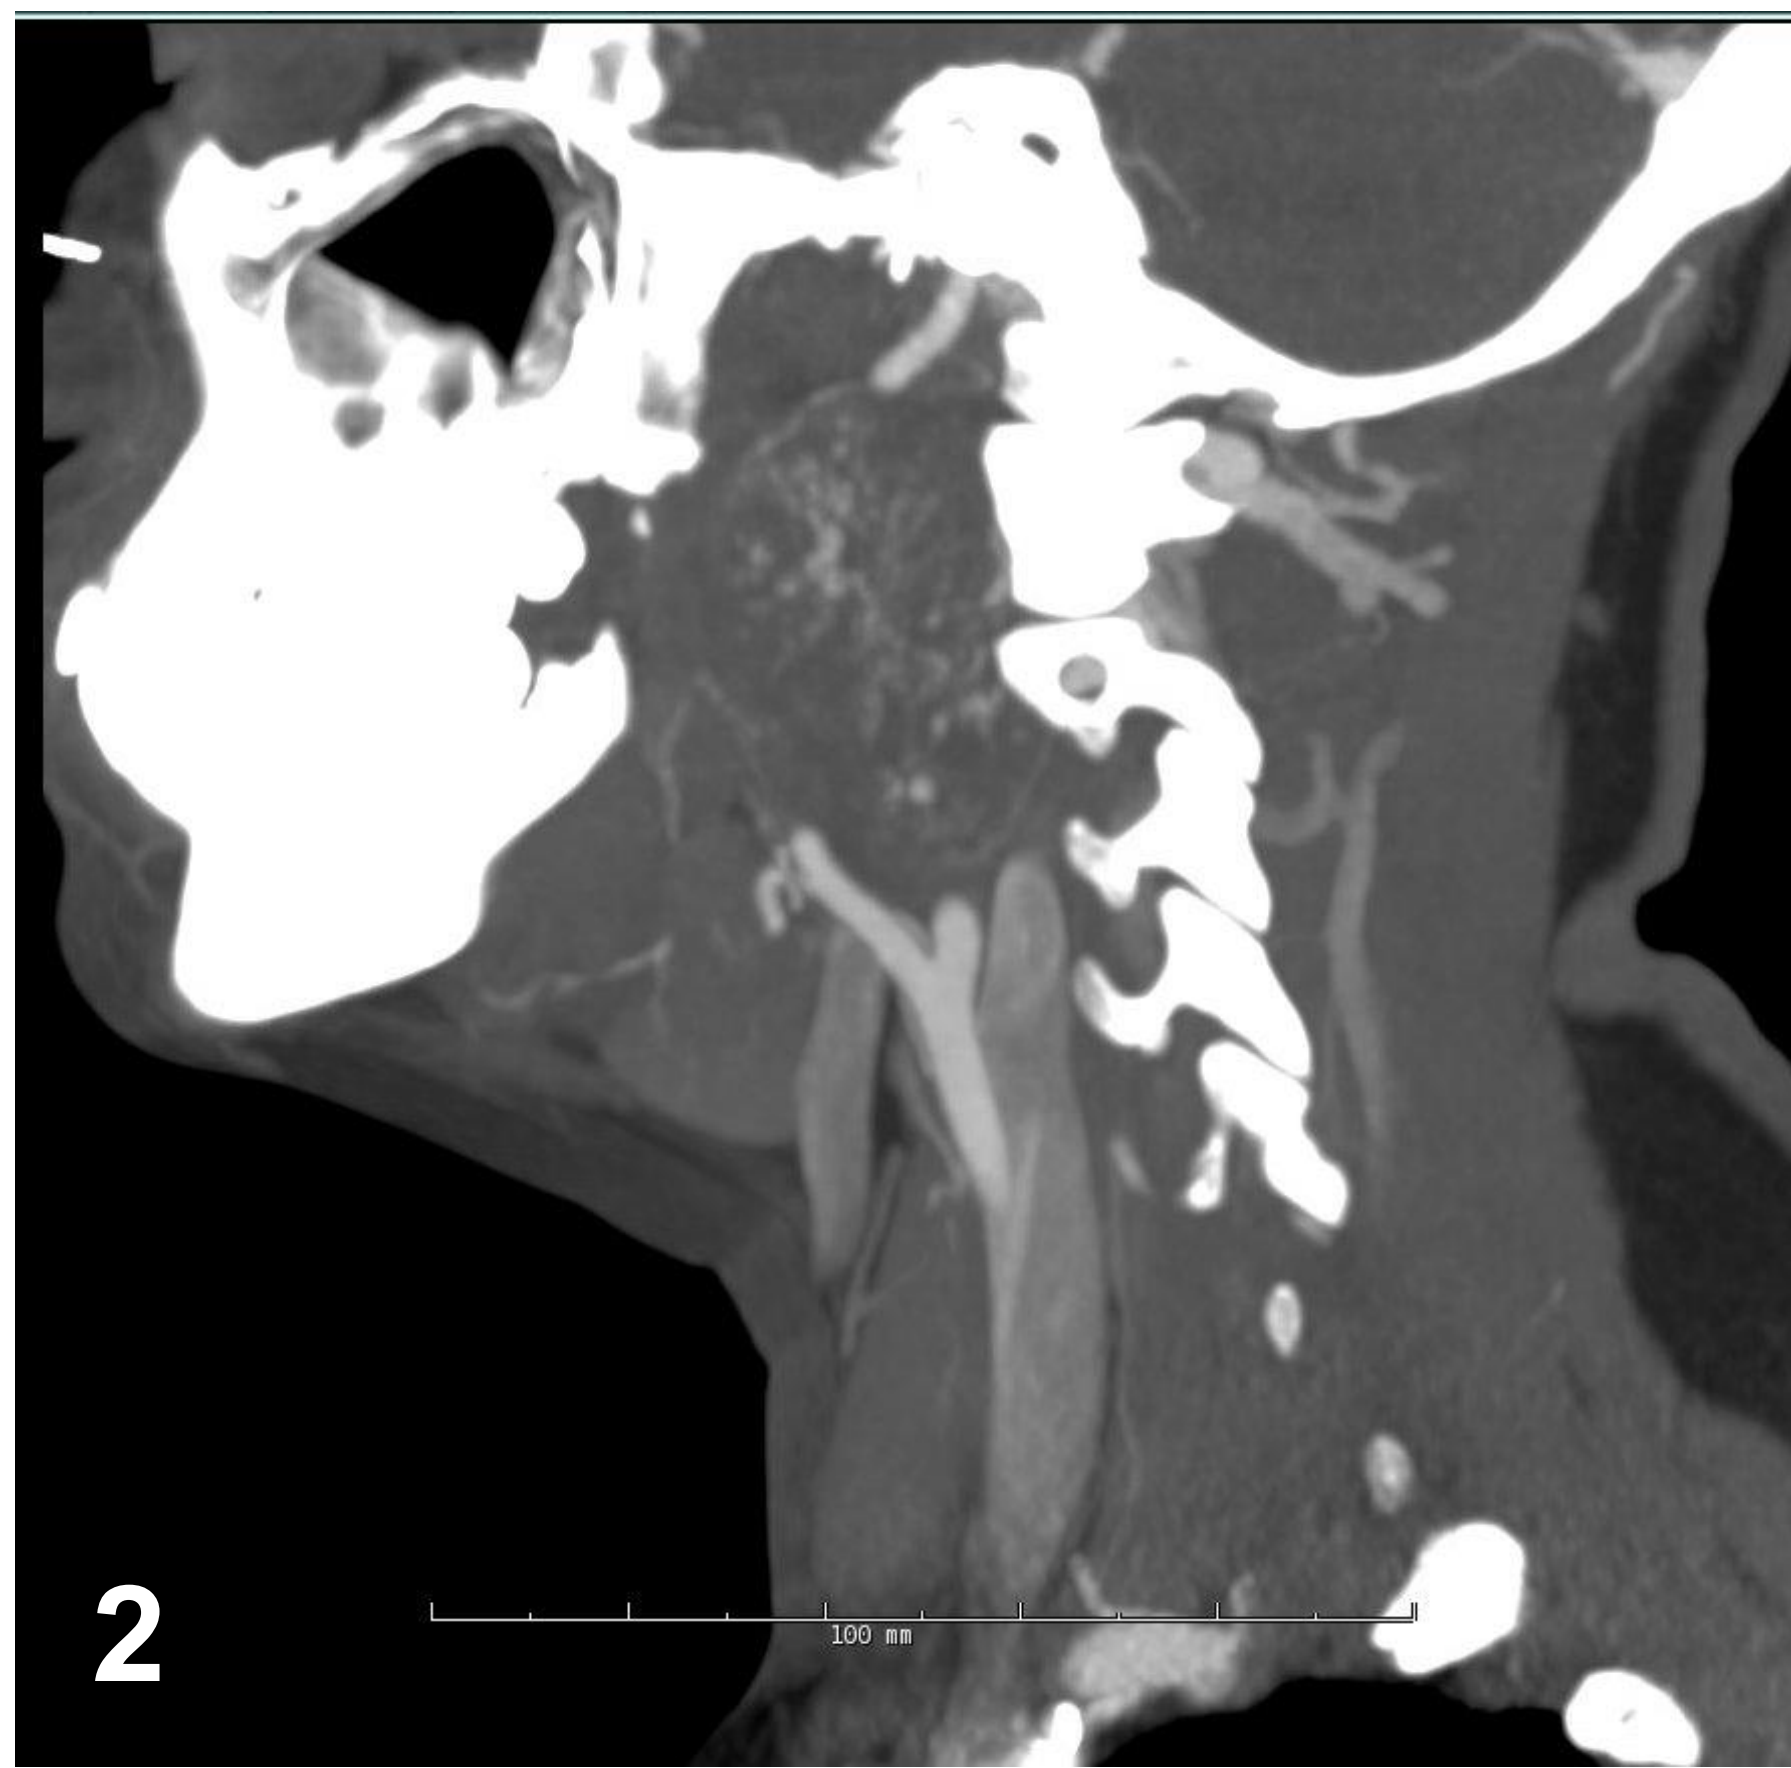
Abnormal CT of right side of neck displaying large mass splaying the internal and external carotid arteries
